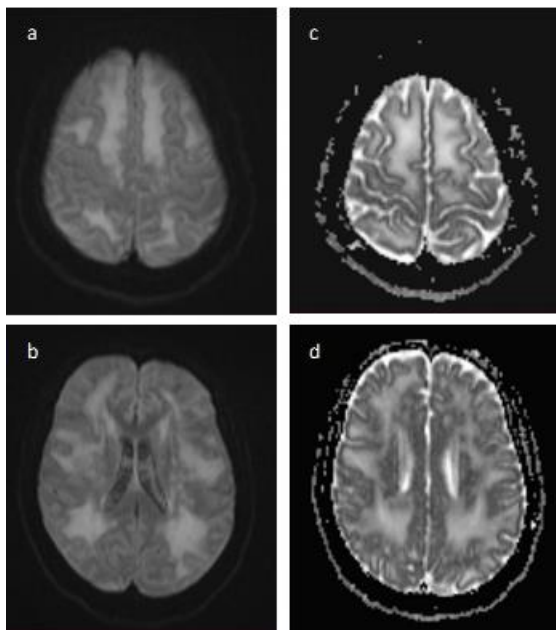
MRI brain axial (a - b) – DWI images and (c - d) – ADC images
